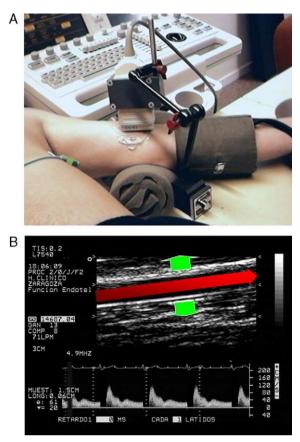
A, Setting for flow-mediated dilation testing. Note the probe position in relation to cuff and the stereotactic apparatus. B, Ultrasound image of braquial artery used to measure both the diameter changes and flow velocity.
